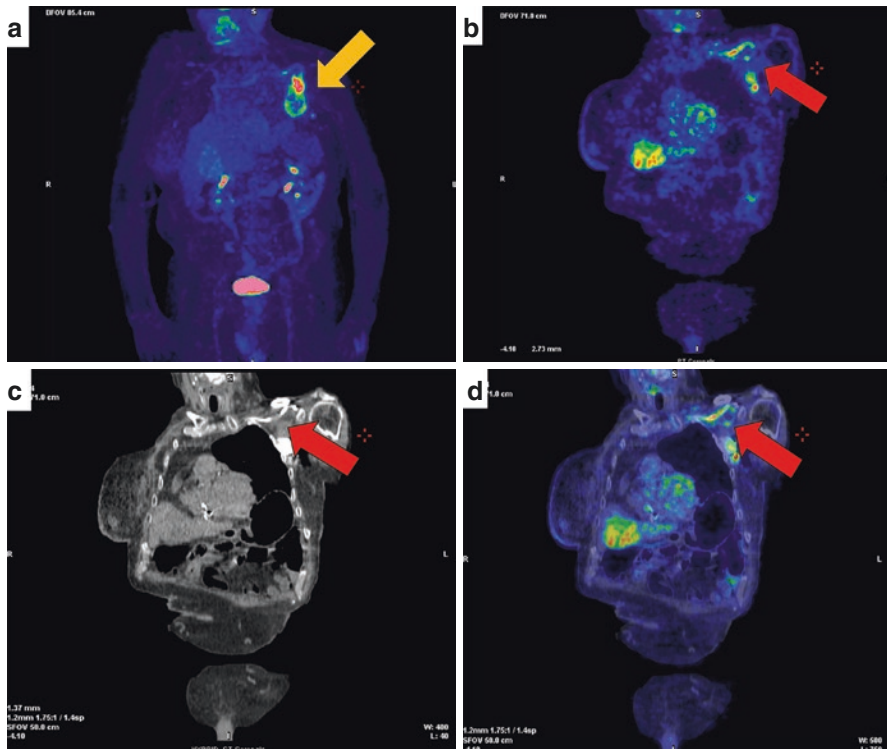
PET/CT scan for the diagnosis of CIEDI. ^{18}F -FDG PET/CT performed in a patient with CIEDI. This scan clearly shows the increased FDG uptake at the pocket site (orange arrow in PET-only anteroposterior image, Panel a). The involvement of the CIED lead is evidenced after proper rotation in a trans-axial image, as evidenced by the red arrow (Panel b=PET-only image; Panel c=CT scan; Panel d = fusion PET/CT)
